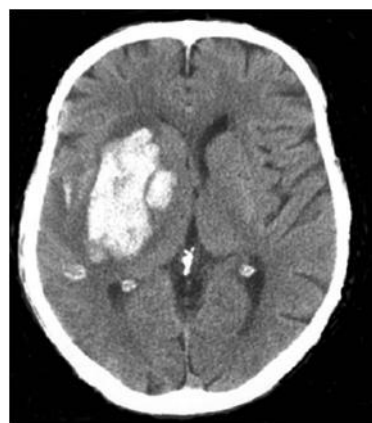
CT brain showing Putamen region hemorrhage
